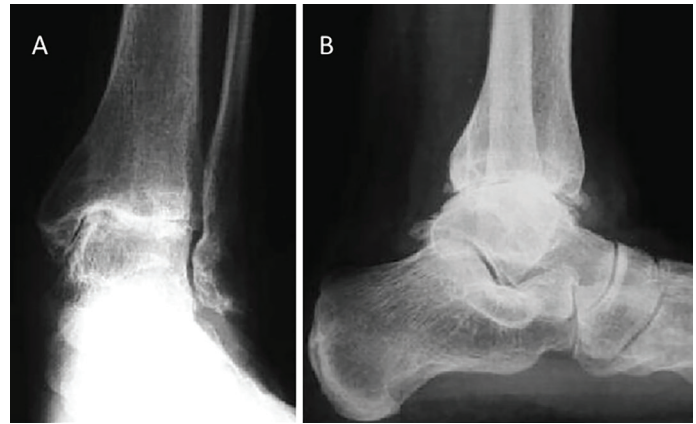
X-Ray Scan of the patient's 2 left ankle joint with grade IV osteoarthritis in frontal (A) and sagittal (B) side
